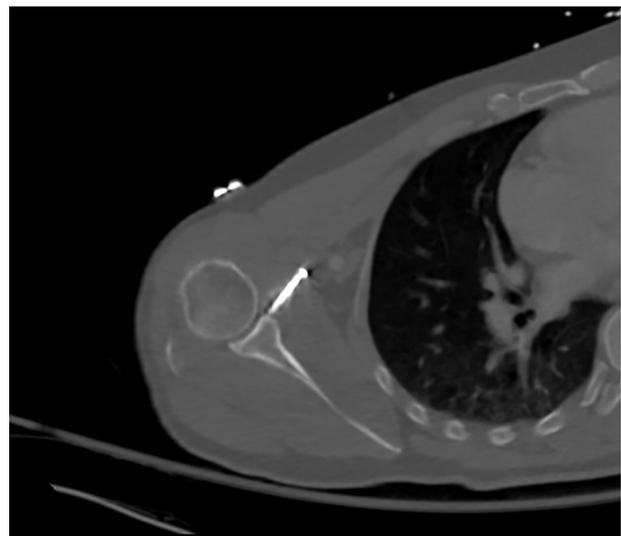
Axial cut of computed tomography angiogram demonstrating pseudoaneurysm of the axillary artery at the location of the screw and evidence of nonunion.
